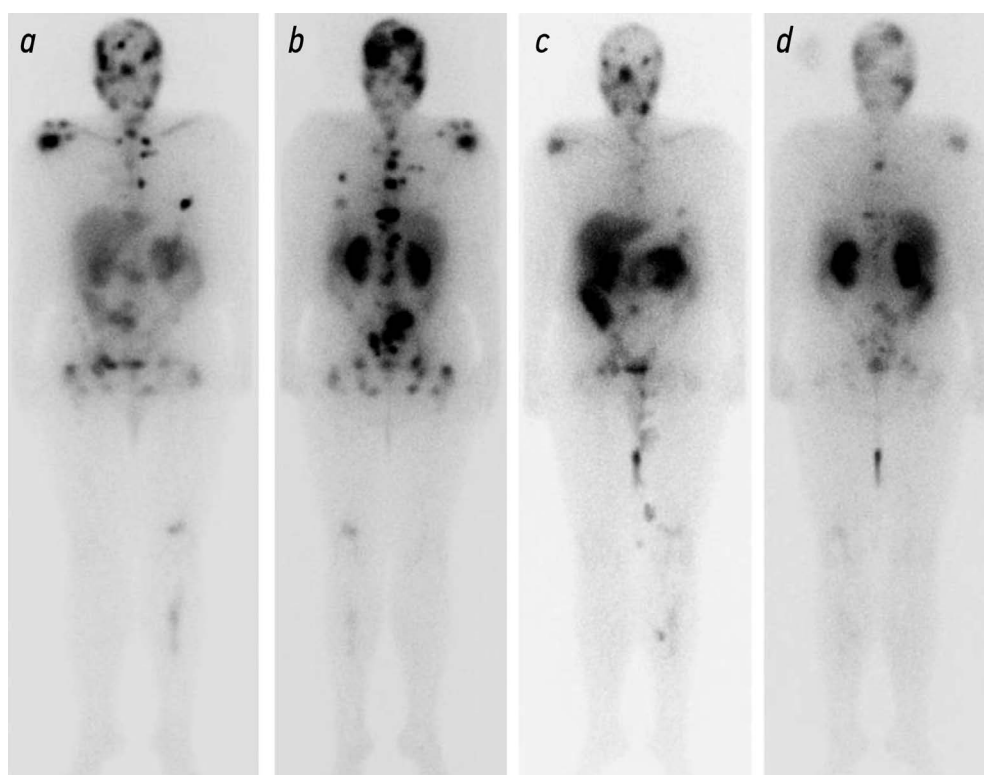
a*, Whole-body scintigraphy with ¹⁷⁷Lu-PSMA, anterior view; *b*, posterior view of December 2021: diffuse-plus-focal radiopharmaceutical hyper uptake of differing intensity, multiple PSMA-positive bone lesions; *c*: whole-body scintigraphy with ¹⁷⁷Lu-PSMA, anterior view; *d*, posterior view of April 2022: reduced radiopharmaceutical uptake in the lesions, absence of new areas of radiopharmaceutical hyper uptake.
